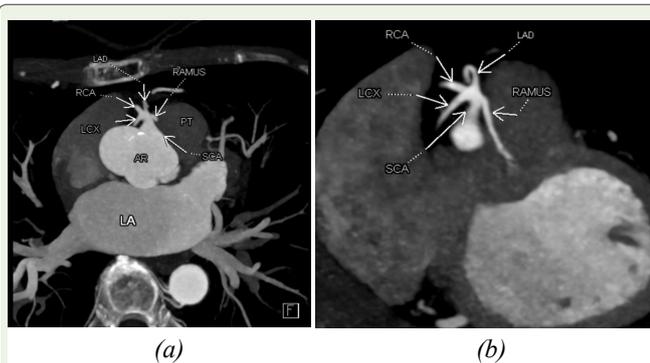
(a) and (b) show oblique reformatted CT angiographic image showing the single coronary artery (SCA) arising from the right coronary sinus. The vessel divides into the right coronary artery (RCA), left anterior descending artery (LAD), left circumflex artery (LCx), and a prominent ramus intermedius (RI). No ostia are seen in the left coronary sinus.
